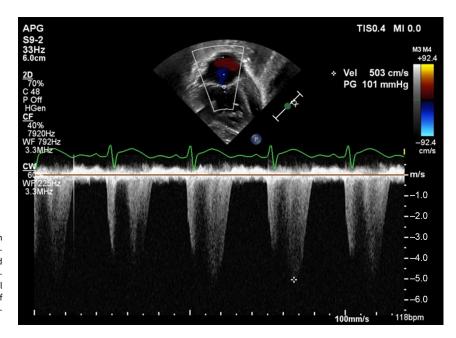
Two-dimensional transthoracic echocardiogram apical view (continuous wave spectral Doppler) on post-operative day 4 after aortic arch reconstruction. The tricuspid regurgitant jet predicted a systolic gradient from the right ventricle to the right atrium of 101 mm of Hg + mean right atrial pressure with a systemic blood pressure at the same time of 75/50 mm of Hg; findings suggestive of supra-systemic pulmonary artery pressures.
